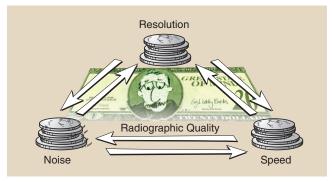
Resolution, noise, and speed are interrelated characteristics of radiographic quality.
